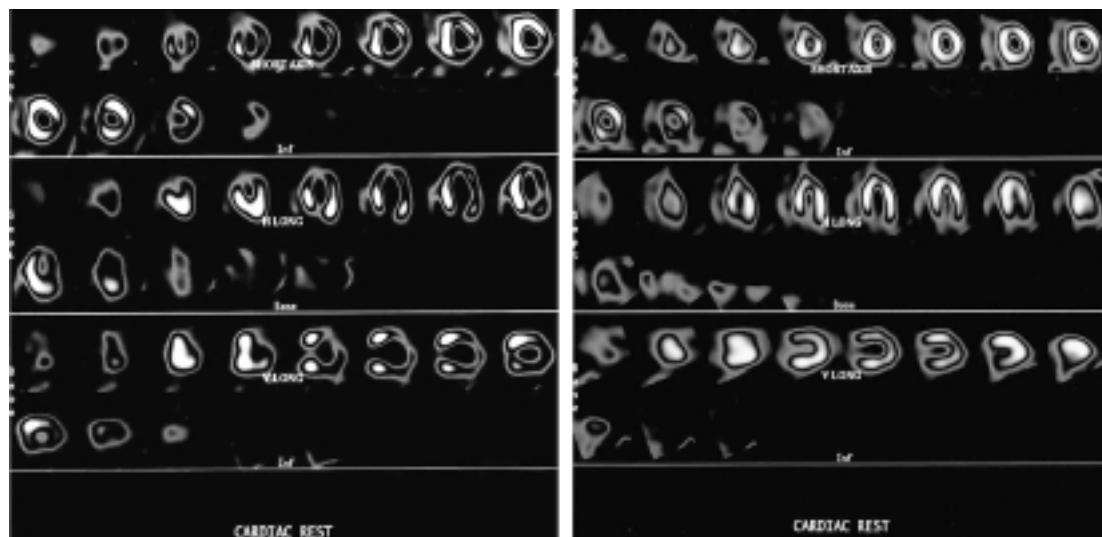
Rest perfusion scintigraphy performed 3 hours following angiography and showing perfusion defects in the apical, anterior and postero-lateral segments and the same technique performed 40 days later and confirming the resolution of the perfusion defects.
